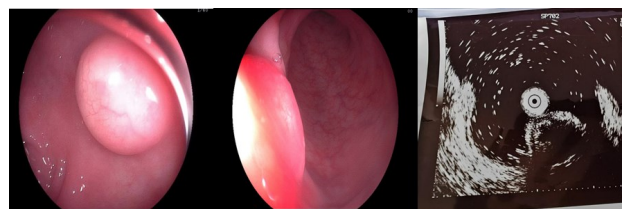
A 58-year-old male patient complained of intermittent, unformed bowel movements for two months. Pathologically diagnosed with a rectal space-occupying lesion (rectal carcinoid, G1). (A, B) Endoscope insertion 4 cm from the anus revealed a 1.2 x 1.5 mm mucosal bulge. The surface was smooth, with small, slightly yellowish-white depressions visible. The texture was firm to the touch. (C) Insertion of the ultrasound probe revealed intact mucosa at the bulge, with an anechoic mass visible in the submucosal layer. The submucosal area had clear boundaries, measuring approximately 7.1 x 11 mm in cross-section, and appeared partially connected to the muscularis propria.
